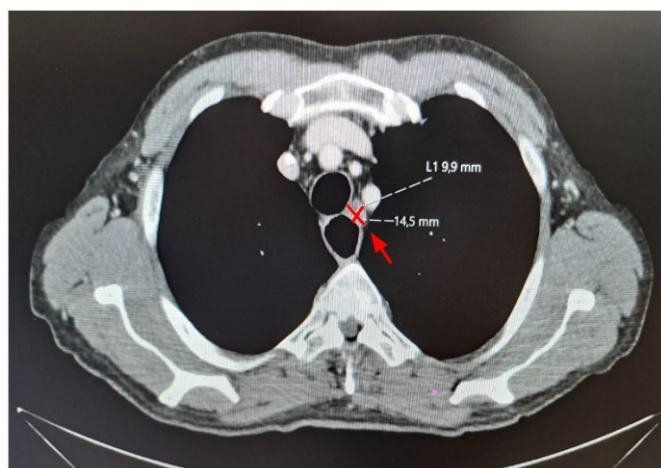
Follow up CT scan shows a single regional recurrence (red arrow).
